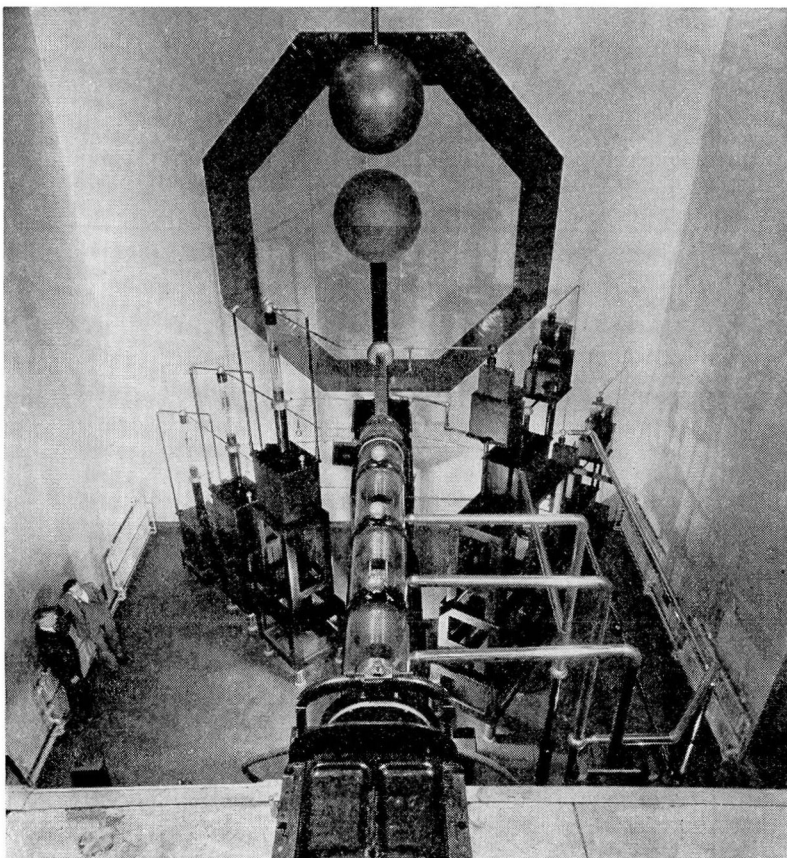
General Electric 800 KV roentgen ray constant potential transformer generator with cascaded glass tube. Target of tube lies under heavy lead cover in front center of picture. Roentgen rays are projected downward into the treatment chamber.
